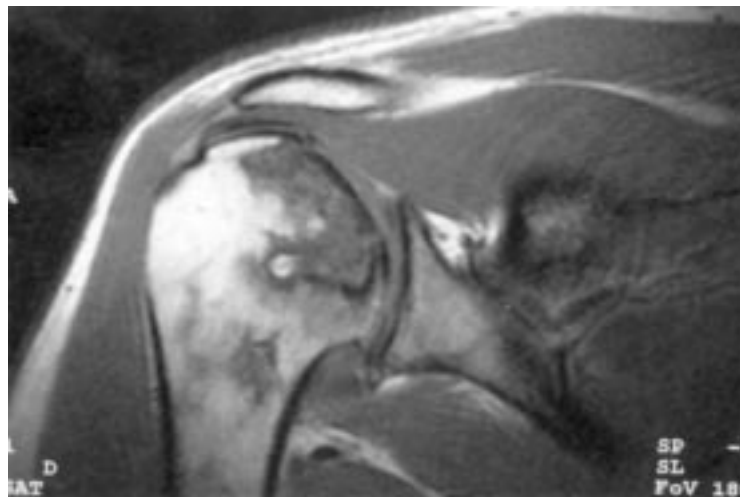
Magnetic resonance image of the right shoulder showing avascular necrosis.
